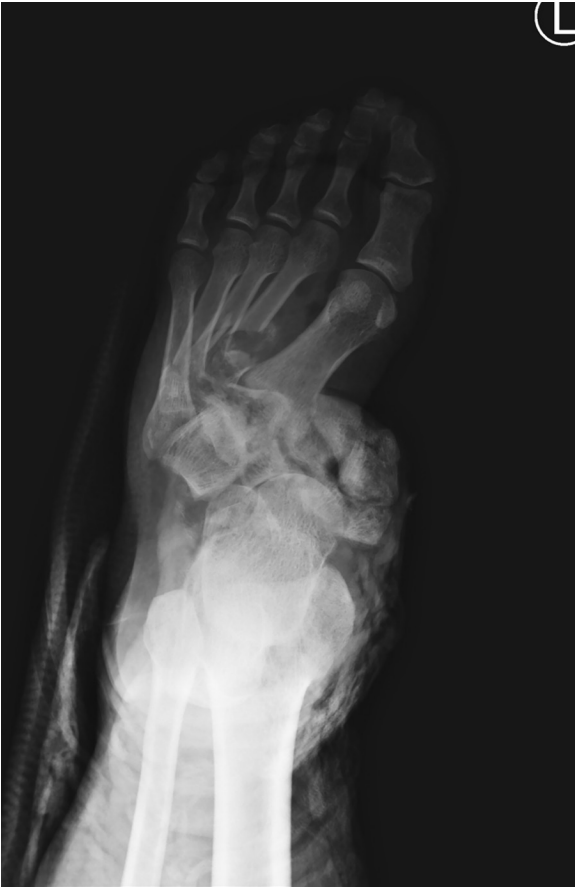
Preoperative radiographic image showing 1st–4th metatarsal bone fractures with dislocation of Lisfranc, intertarsal, and transverse tarsal joints.
